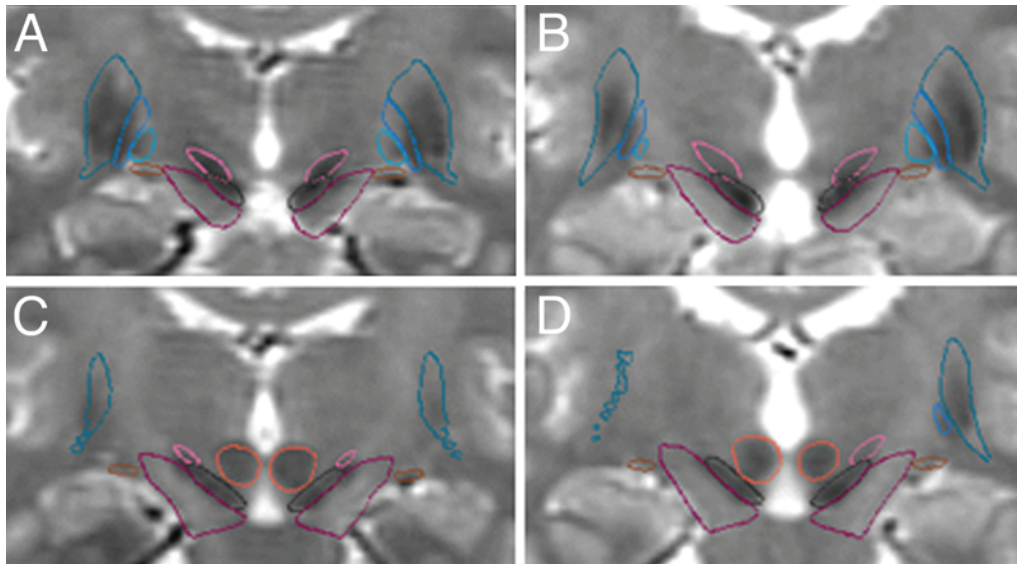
Standardized visual inspection of deformed atlas structures in T2-weighted MR images. The T2-weighted MR image was automatically coregistered with the T1-weighted MR image (used to deform the atlas), thus allowing comparison of STN (pink), SN (black), and RU (red) contours with hypointense areas. Images obtained in 2 patients are presented (left and right boxes). For each case, 2 coronal slices are presented: 1 through the center of RU (C and D), and 1 anterior to RU (A and B). The contours of the putamen and globus pallidus are in blue, that of the cerebral peduncle in fuchsia.
